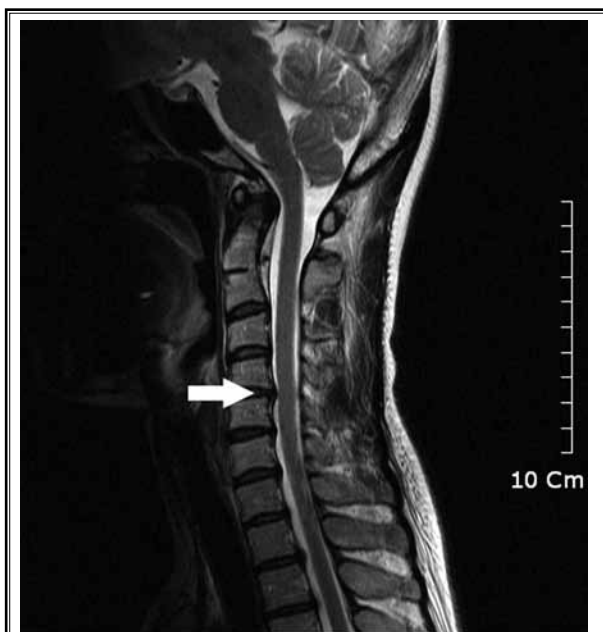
A 43-year-old woman with cervical canal stenosis. Sagittal T2-weighted fast spin-echo image shows grade 1 stenosis with obliteration of CSF space exceeding 50% of the arbitrary subarachnoid space at the C4-5 level (arrow).
